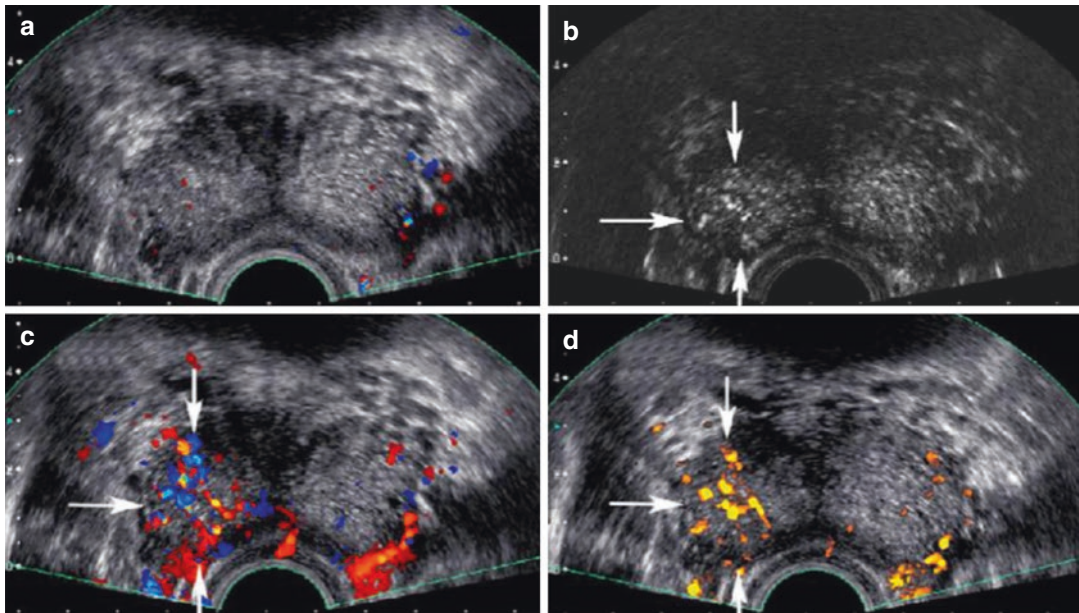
A 62-year-old. (a) The image with gray scale does not identify neoplasms. (b) Power Doppler image after administration of contrast medium. (c) Power color Doppler after administration of contrast medium. (d) The CEUS image evidences a significant increase of vascularization (*arrows*)
